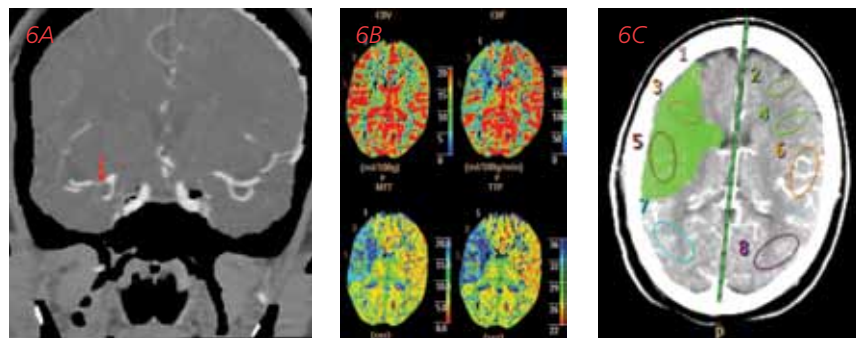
(A) Computed tomography (CT) angiogram. Coronal maximum intensity projections demonstrate an area of severe right M2 stenosis (arrow) in a patient with left-sided stroke symptoms that began more than six hours ago. (B) CT perfusion. Special contrast sequences can be obtained that evaluate the flow of blood in the brain tissue and the amount of blood in the brain tissue. CBF = cerebral blood flow, CBV = cerebral blood volume, MTT = mean transit time, P = posterior, TTP = time to peak. (C) An area of "perfusion mismatch," which identifies tissue with an insufficient blood supply that is still viable and salvageable.
